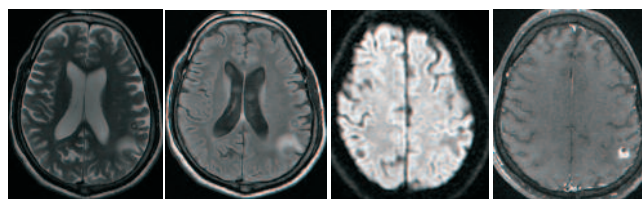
a) T2WI Axial (b) FLAIR Axial (c) DW Axial (d) Postcontrast T1WI Fat Sat Axial
